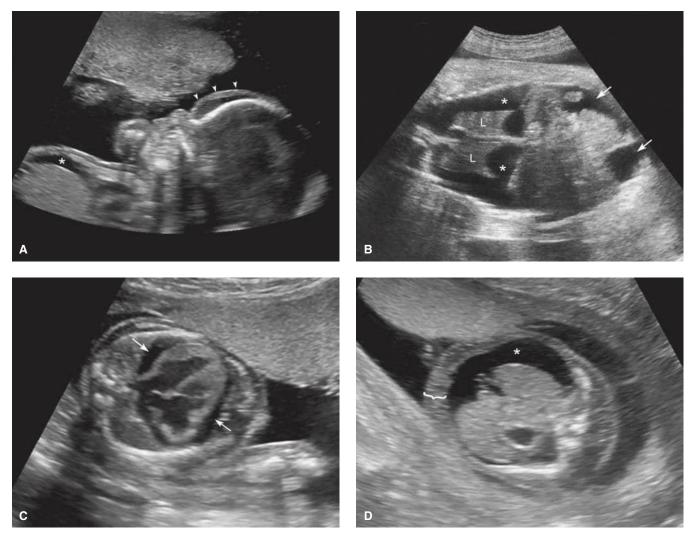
Sonographic findings that define hydrops. A. This profile of a 23-week fetus with nonimmune hydrops secondary to B19 parvovirus infection depicts scalp edema (*arrowheads*) and ascites (*). B. This 34-week fetus had hydrops secondary to an arteriovenous malformation in the brain, known as a vein of Galen aneurysm. In this coronal image, prominent pleural effusions (*) outline the lungs (L). Fetal ascites is also present (*arrows*), as is anasarca. C. This axial (transverse) image depicts a pericardial effusion (*arrows*) in a 23-week fetus with hydrops from B19 parvovirus infection. The degree of cardiomegaly is impressive, and the ventricular hypertrophy raises concern for myocarditis, which can accompany parvovirus infection. D. This axial (transverse) image depicts fetal ascites (*) in a 15-week fetus with hydrops secondary to large cystic hygromas. Anasarca is also seen (*bracket*).
